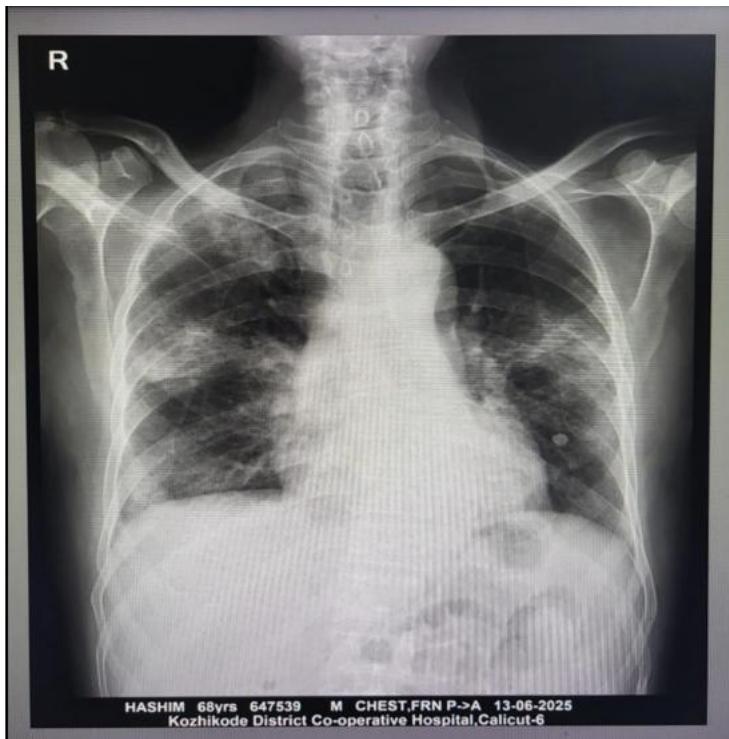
Chest x-ray showing atypical pneumonia.
